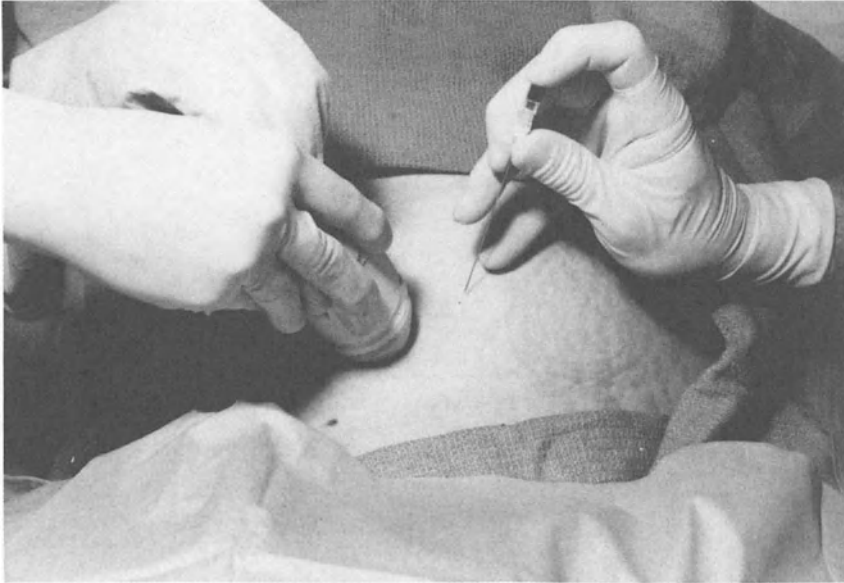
Percutaneous umbilical blood sampling: dual operator using sector ultrasound.
